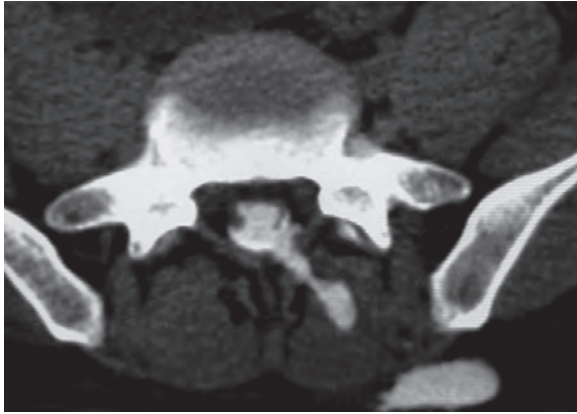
A young man was knifed in the buttock. There was no neurological impairment. The entry wound in the upper gluteal region was sutured elsewhere. CSF leaked out of the wound 4 days later. CT myelography showed the dural fistula at L5-S1 level with a subcutaneous collection. He made uneventful recovery after dural repair through laminotomy
